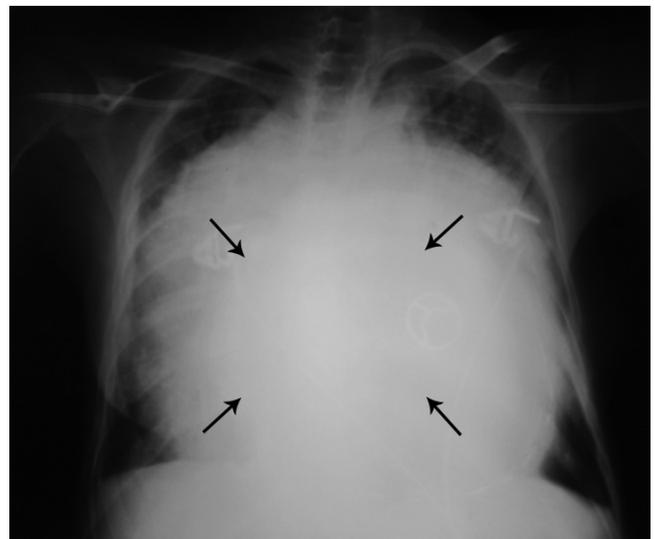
Chest X-Ray in posteroanterior view, showing a huge left atrium cardiomegaly (arrows)
